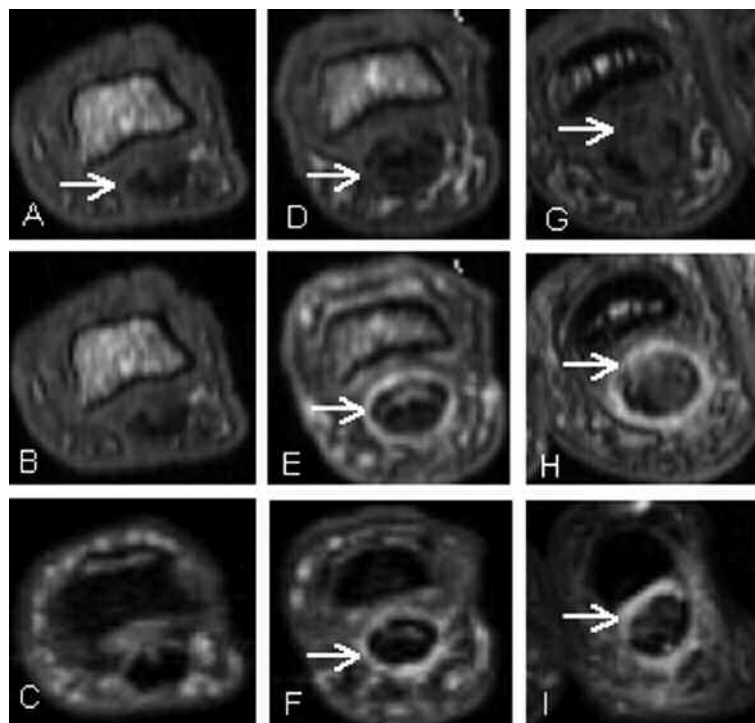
Tenosynovitis (a-c: grade 0; d-f: grade 1; g-i: grade 2) assessed at the level of the PIP joints. Images are in the axial plane (upper row: pre-contrast T1-weighted; middle row: post-contrast T1-weighted; lower row: STIR).
